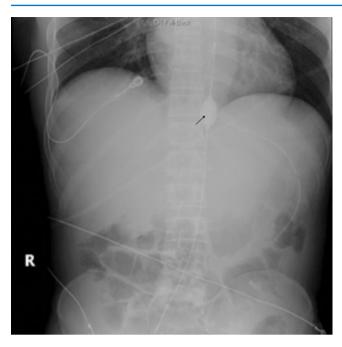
KUB radiograph demonstrating REBOA balloon in zone 1 (arrow)
